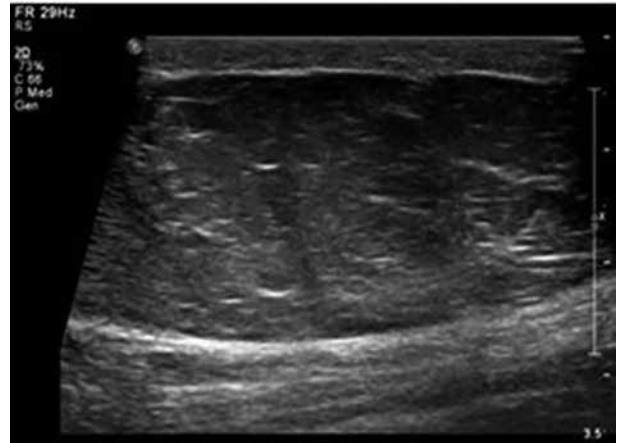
Lipoma – greyscale ultrasound image shows a large, well-defined hyperechoic lesion with few linear echogenic foci within in the subcutaneous plane
